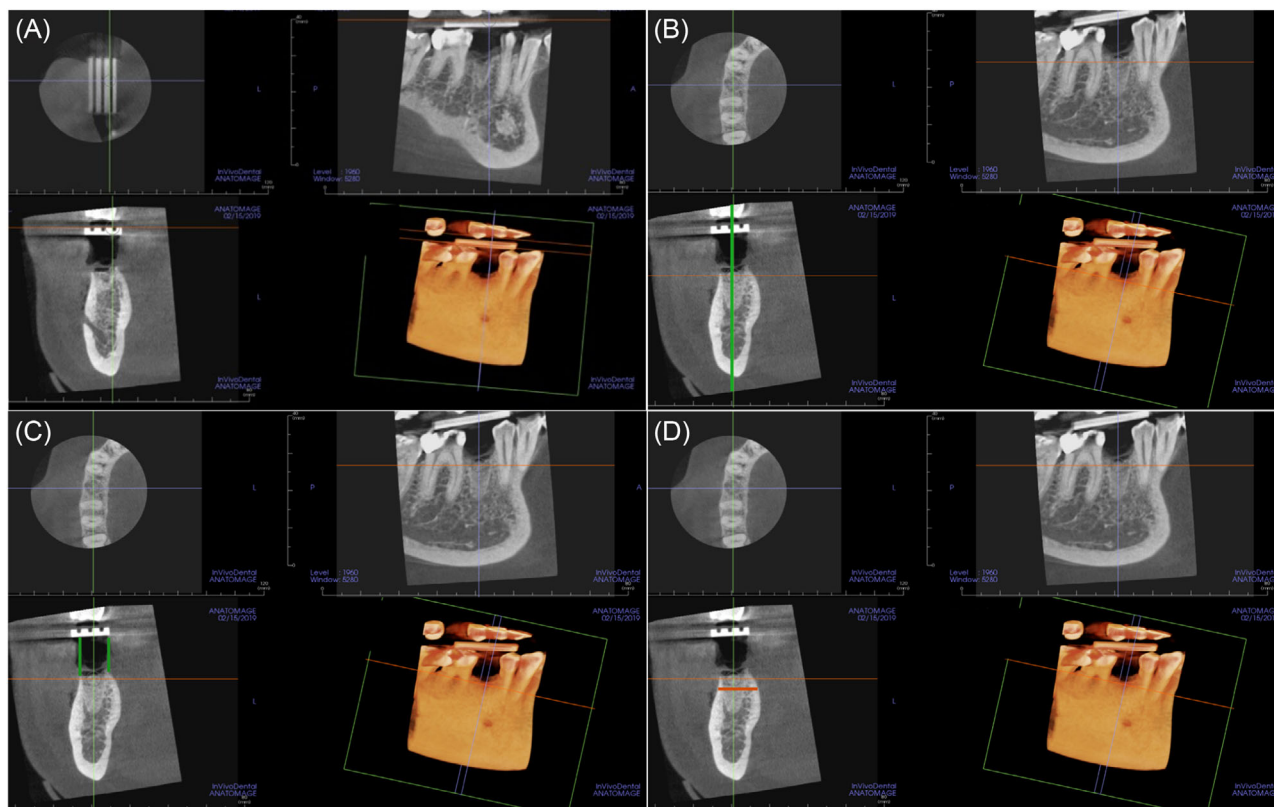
Radiographic measurements made on a baseline CBCT. Similar measurements were made for all baseline and final CBCTs. (A) Alignment of radiographic marker parallel to the axial, sagittal, and coronal plane slices. (B) Sagittal and coronal planes aligned parallel to the long axis of the extraction socket and socket midpoint determined. (C) Vertical height measurements made from fixed points on radiographic marker. (D) Horizontal width measurements made 3, 5, and 7 mm apical to crest
